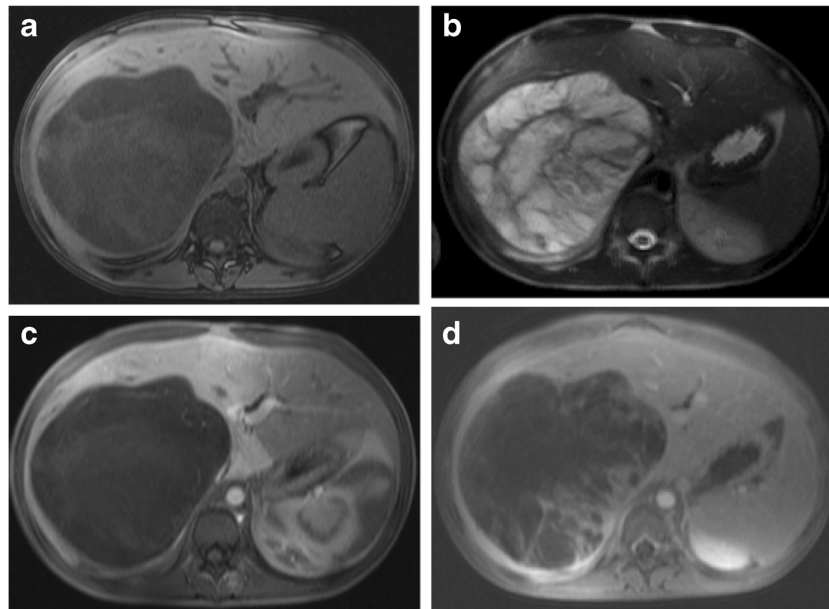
Undifferentiated embryonal sarcoma in a 17-year-old female. Transverse T1-weighted fat-suppressed three-dimensional (3D) gradient echo (GRE) (a), T2-weighted fat-suppressed single-shot echo train spin echo (b), post-gadolinium fat-suppressed T1-weighted late hepatic arterial phase (c) and equilibrium phase (d) 3D GRE images. A large
